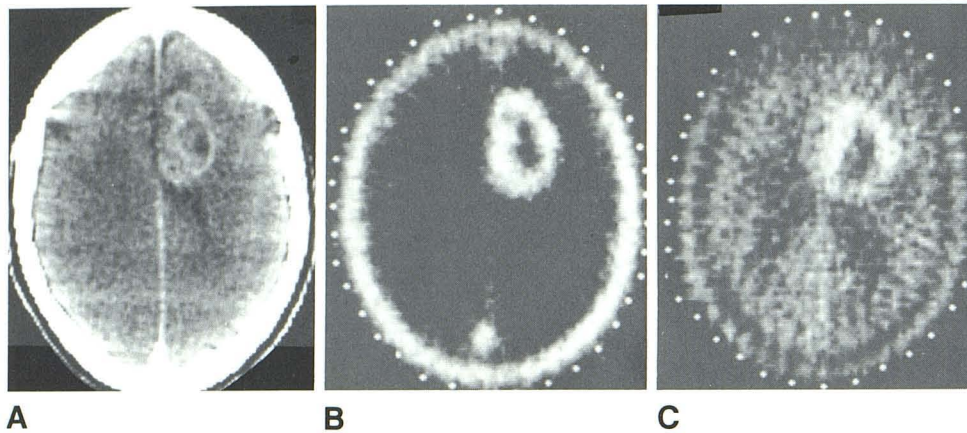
Case 6. Astrocytoma grade III. Good correspondence between enhanced CT scan (A), ^{68}Ga -EDTA PET scan (B), and ^{11}C -L-methionine PET scan (C).
